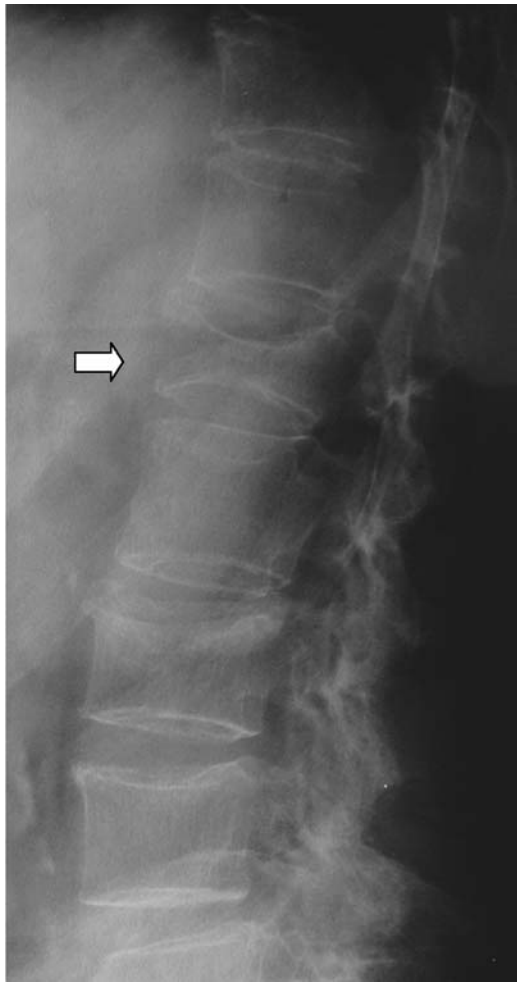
Preoperative radiograph, lateral view, vertebral collapse on L1 level.
